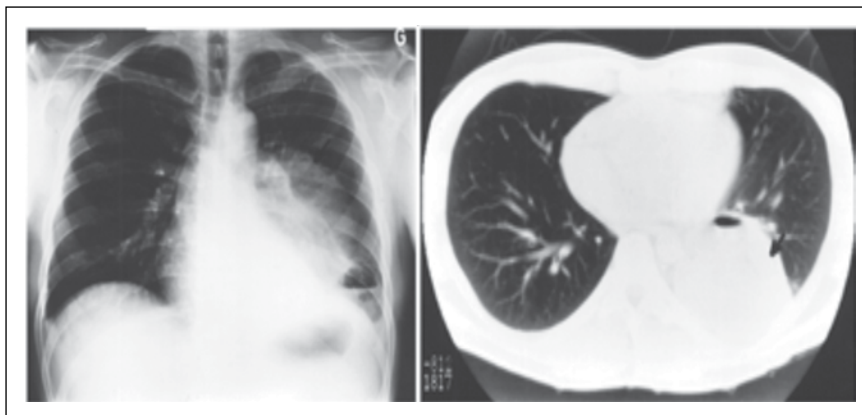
Chest x-ray with radiodensity in the left lower zone, CT showing the mass in the same patient
